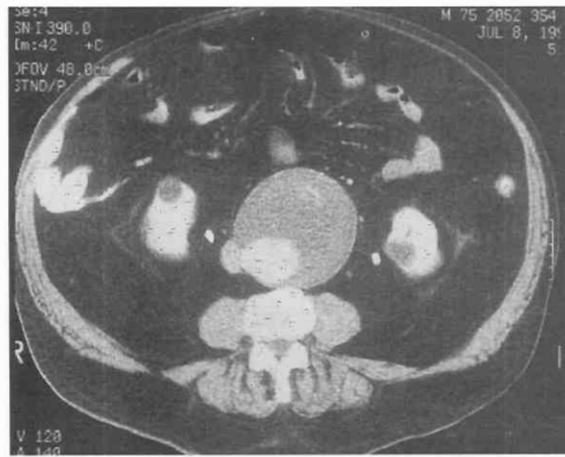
Abdominal aortic aneurysm. Dynamic, intravenous contrast-enhanced CT scan demonstrates a large amount of thrombus within the aneurysm. Some of the thrombus is calcified. An arteriogram on this patient would significantly underestimate the size of the aneurysm because only the patent part of the lumen containing flowing blood would be opacified.
